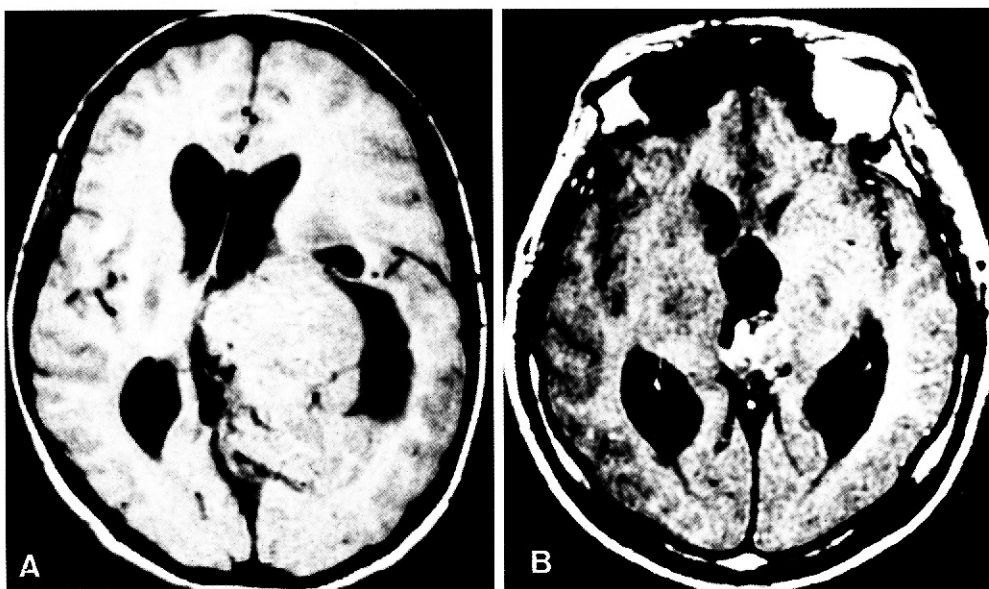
Papillary ependymoma : A (Case 1) : T1 weighted MRI shows an irregularly outlined heterogeneous mass in the left lateral ventricle with high signal intensity spots in the center of the mass, B (Case 2) : Enhanced T1 weighted MRI shows a mildly enhanced, 3cm sized solid mass with calcification, mainly in the 3rd ventricle and pineal area, accompanied with hydrocephalus.
